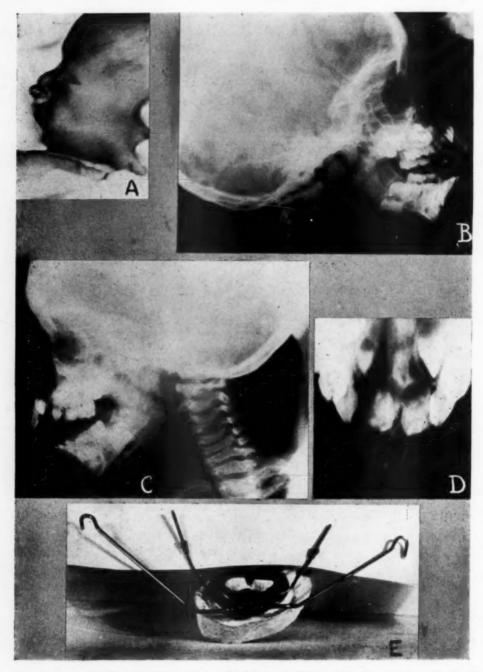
A, Profile of colored baby with bilateral cleft. (Courtesy of Carl G. Burdick, M.D.) B, Left lateral profile x-ray. C, Right lateral profile x-ray. D, Occlusal film. Permanent maxillary central incisor appears to be hypoplastic. There is no evidence of permanent lateral incisors. E, Appliance with vulcanite saddle and labial bitlike extension for extraoral elastics.
